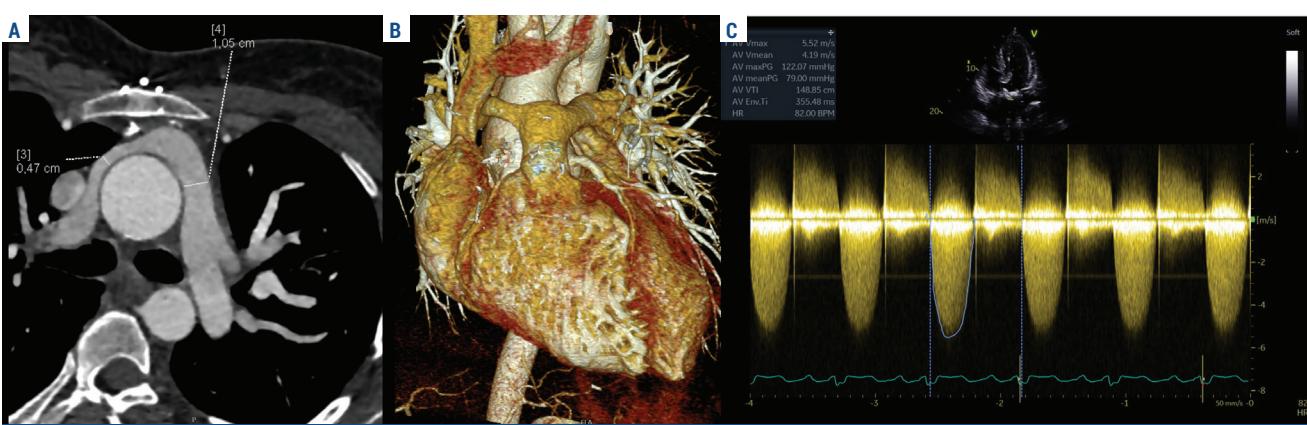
CT scan (A, B) and echocardiography of a patient with transposition of great arteries after a "switch" surgery, resulting in right pulmonary artery stenosis caused by aortic dilatation.
